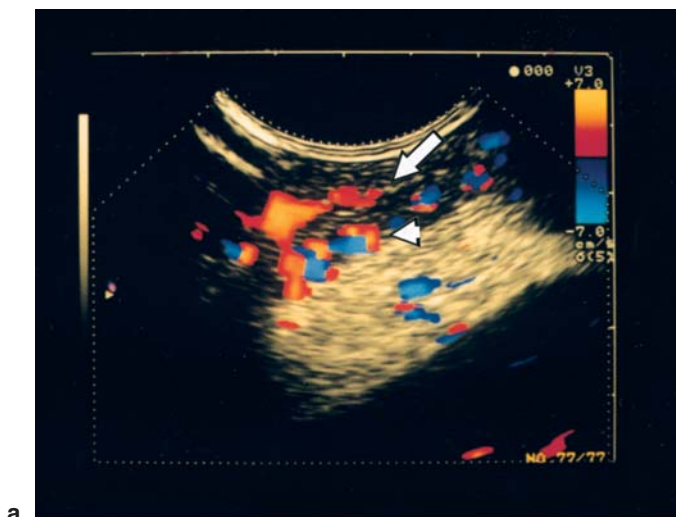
a Vessel images of esophageal varices (*arrow*) and paraesophageal veins are detected via pre-contrast endoscopic color Doppler ultrasonography. b Vessel image of inflow-type perforating vein (*arrow*) can be discerned with endoscopic color Doppler ultrasonography after administration of Levovist contrast
